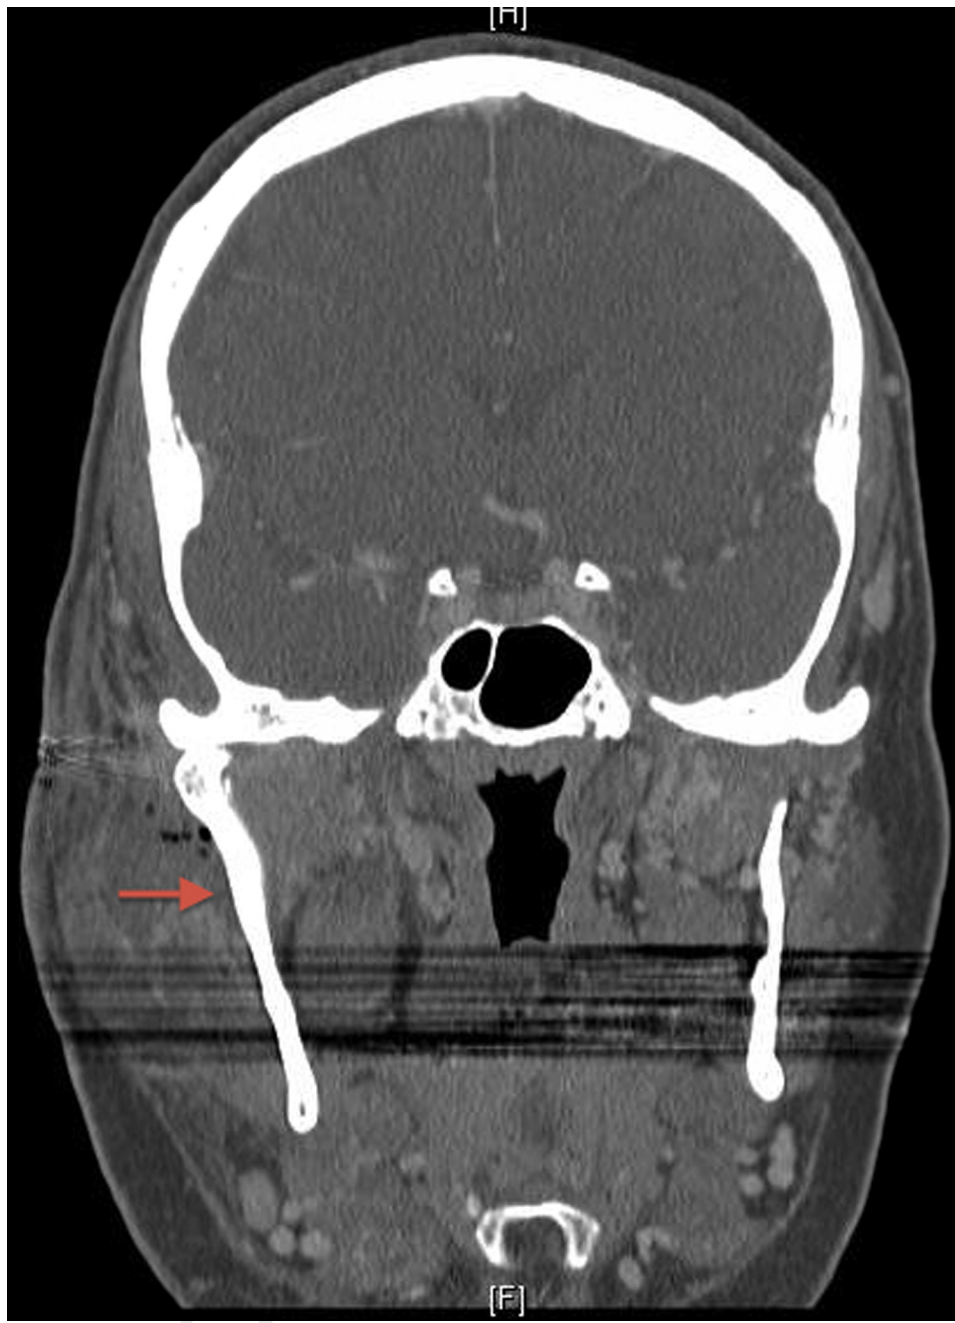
Case 2. Maxillofacial contrast-enhanced coronal computed tomogram on day 58 after the first surgery, but before the second surgery, shows a residual abscess (arrow) lateral to the right condyle.
